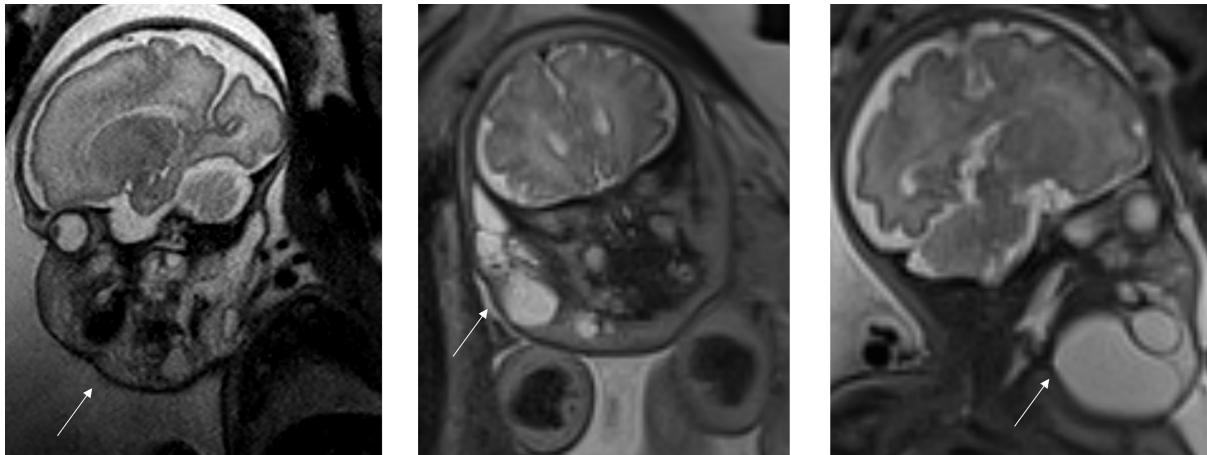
Fetal MRI images of lymphatic malformation
